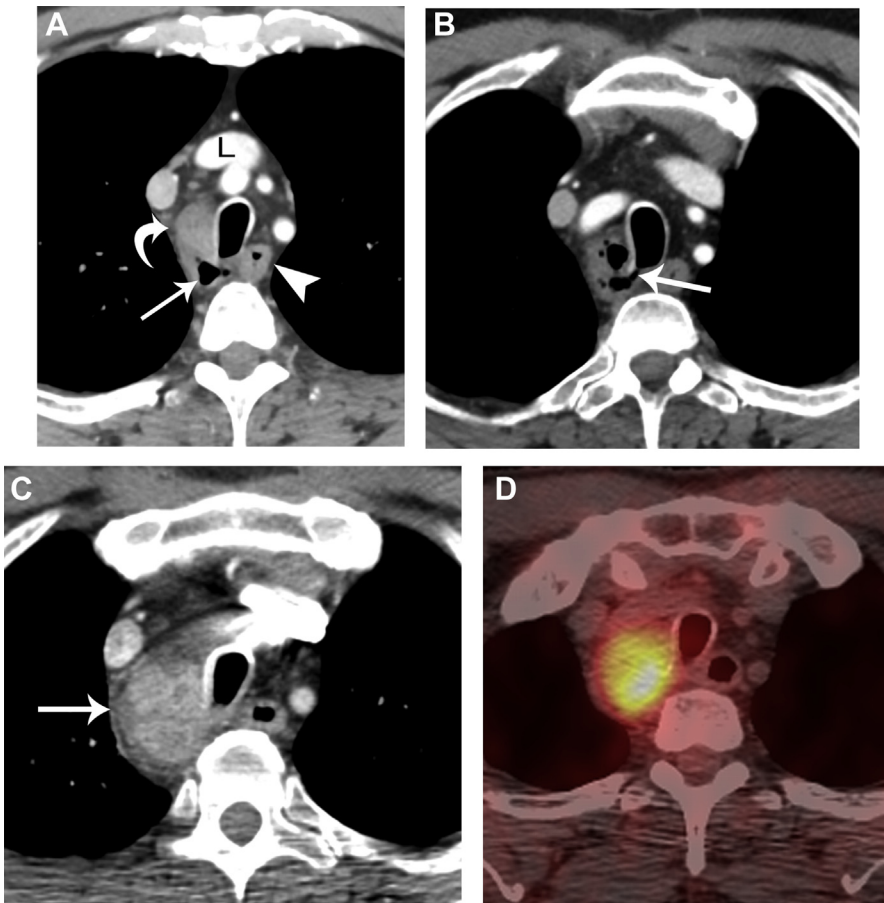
Tracheal diverticulum in a 52-year-old man with undifferentiated sinonasal carcinoma. (A) A contrast-enhanced axial CT scan of the chest at the level of the left brachiocephalic vein (L) demonstrates apparent soft tissue in the right paratracheal region mimicking lymphadenopathy (*curved arrow*). However, upon closer scrutiny, a pocket of air (*straight arrow*) separate from the esophagus (*arrowhead*) is noted. (B) A contrast-enhanced axial CT scan of the chest cephalad to the prior image demonstrates that the apparent soft tissue in the right paratracheal region actually represents a fluid-filled tracheal diverticulum. Note the air-filled stalk (*arrow*) connecting this lesion to the tracheal lumen. (C) A contrast-enhanced axial CT scan of the chest performed 6 days later shows that the tracheal diverticulum (*arrow*) has increased in size, contains more fluid but less air, and enhances heterogeneously. This CT scan was performed 3 days after bronchoscopy in which the diverticulum was brushed and biopsied. (D) A fused axial FDG PET/CT scan performed after the bronchoscopy shows increased FDG uptake in the paratracheal lesion that could be misinterpreted as a neoplasm. However, this uptake was due to inflammation from a recent invasive procedure. The tracheal diverticulum decreased in size and FDG avidity on subsequent studies (not shown).
